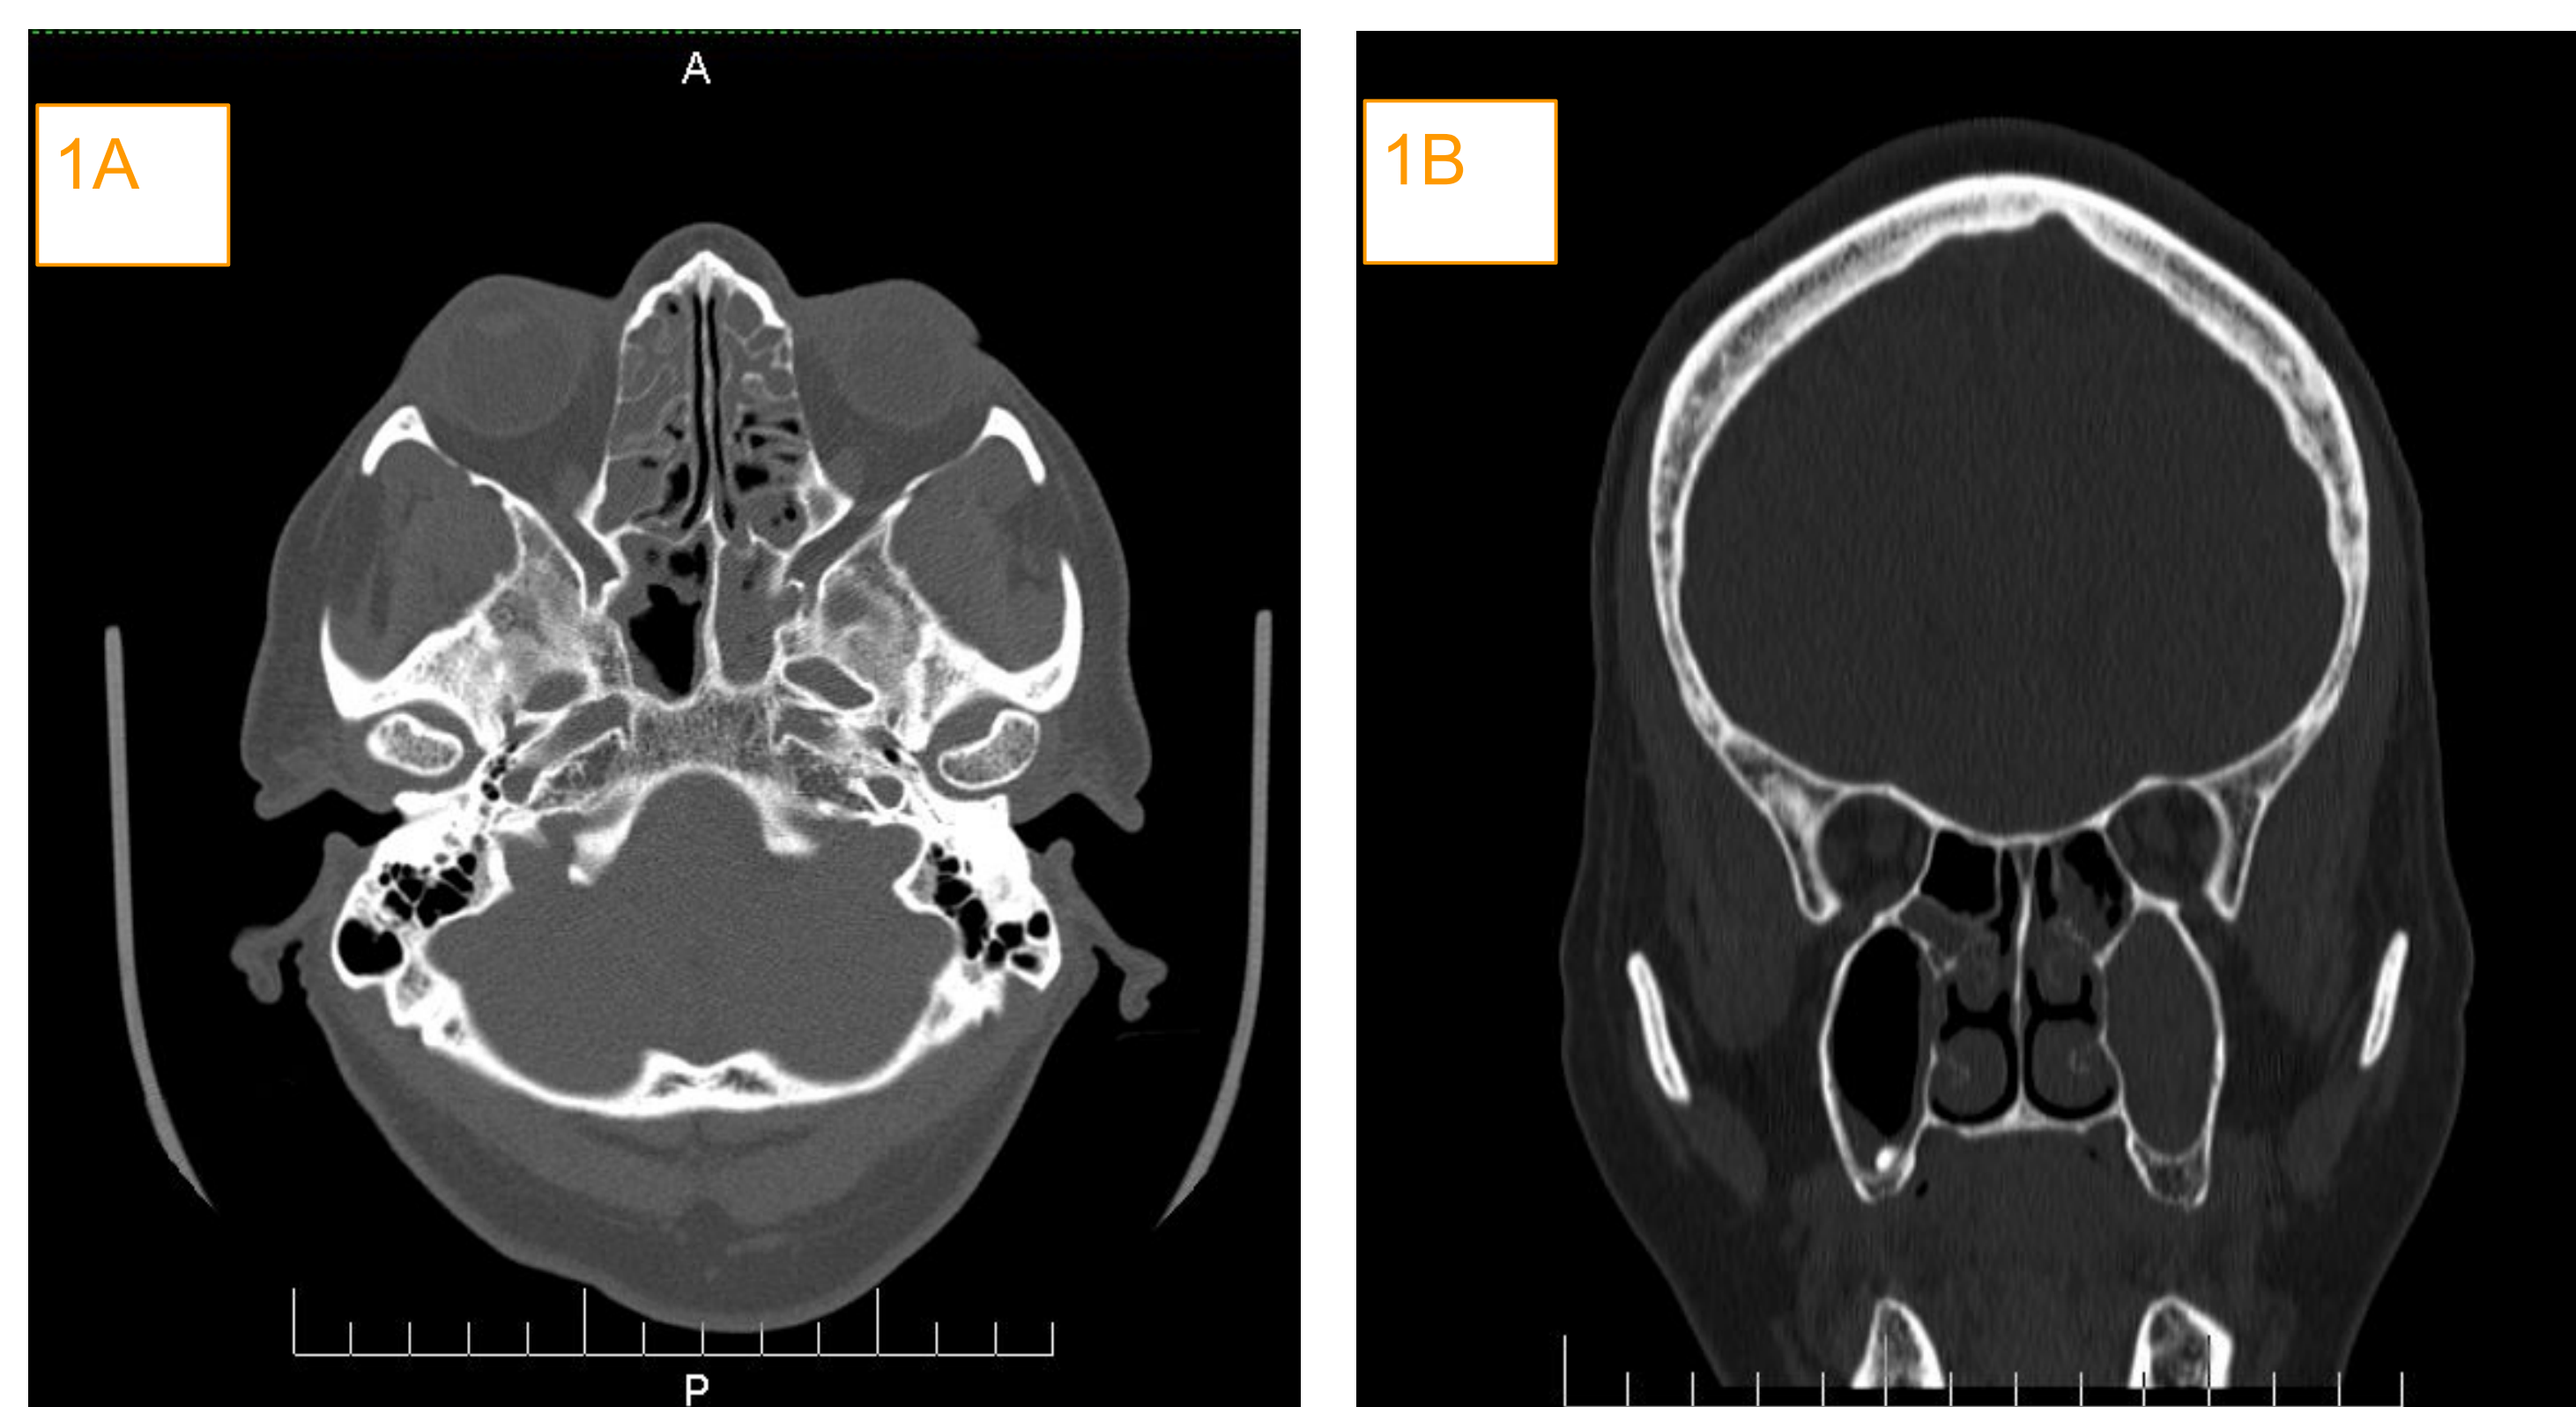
Computed Tomography of the Paranasal Sinuses Obtained Prior to Endoscopic Sinus Surgery. 1A is an axial CT image revealing near complete ethmoid and left greater than right sphenoid sinus opacification with mucosal thickening. 1B is a coronal CT image revealing complete left maxillary sinus opacification and turbinate hypertrophy. Polyp burden unable to be appreciated on pre-op CT imaging.
